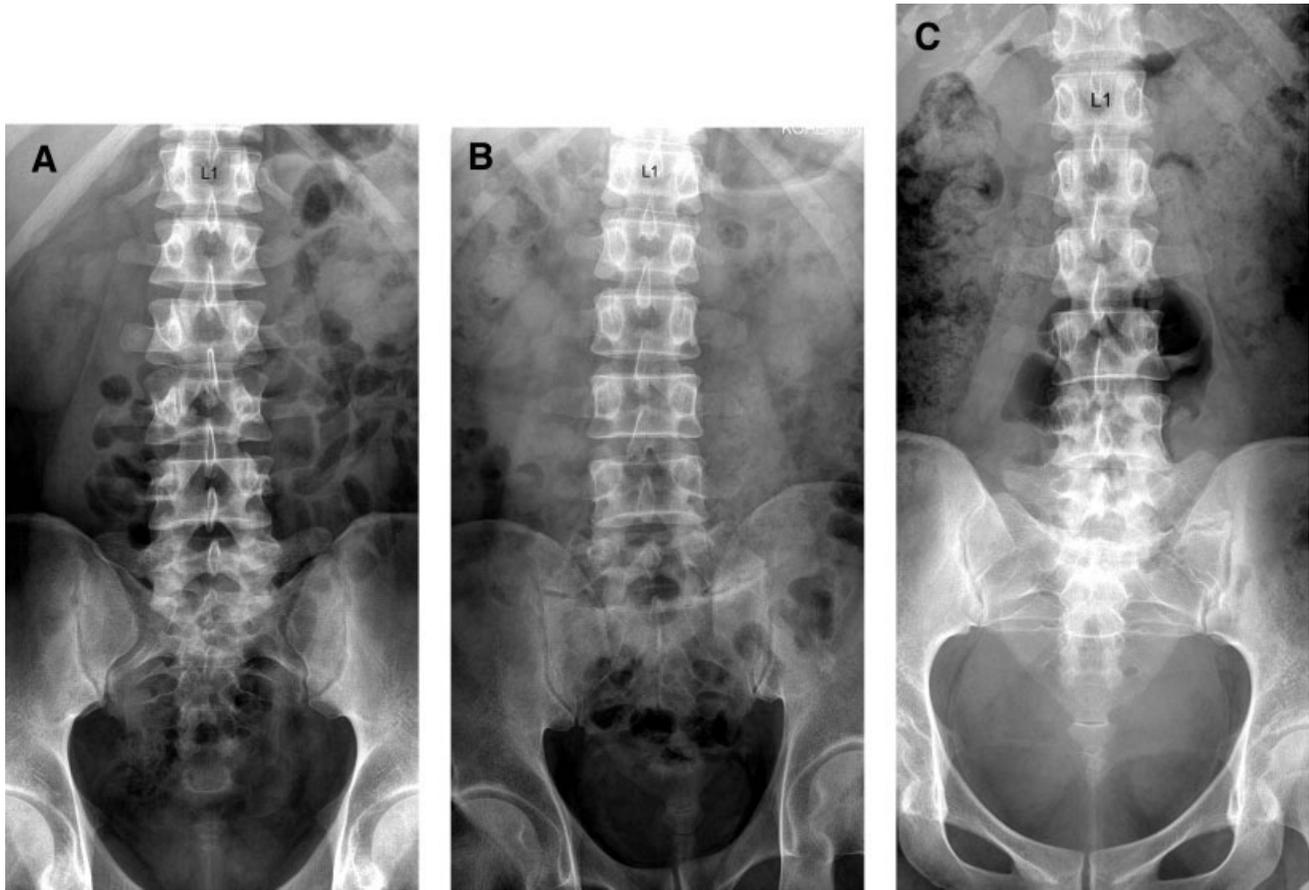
Type of lumbarization. A: Complete lumbarization. Lumbar AP radiograph shows a completely separated transverse process of the S1 vertebra. The accessory of a 13th rib is also revealed. B: Incomplete lumbarization. Lumbar AP radiograph reveals bilateral
